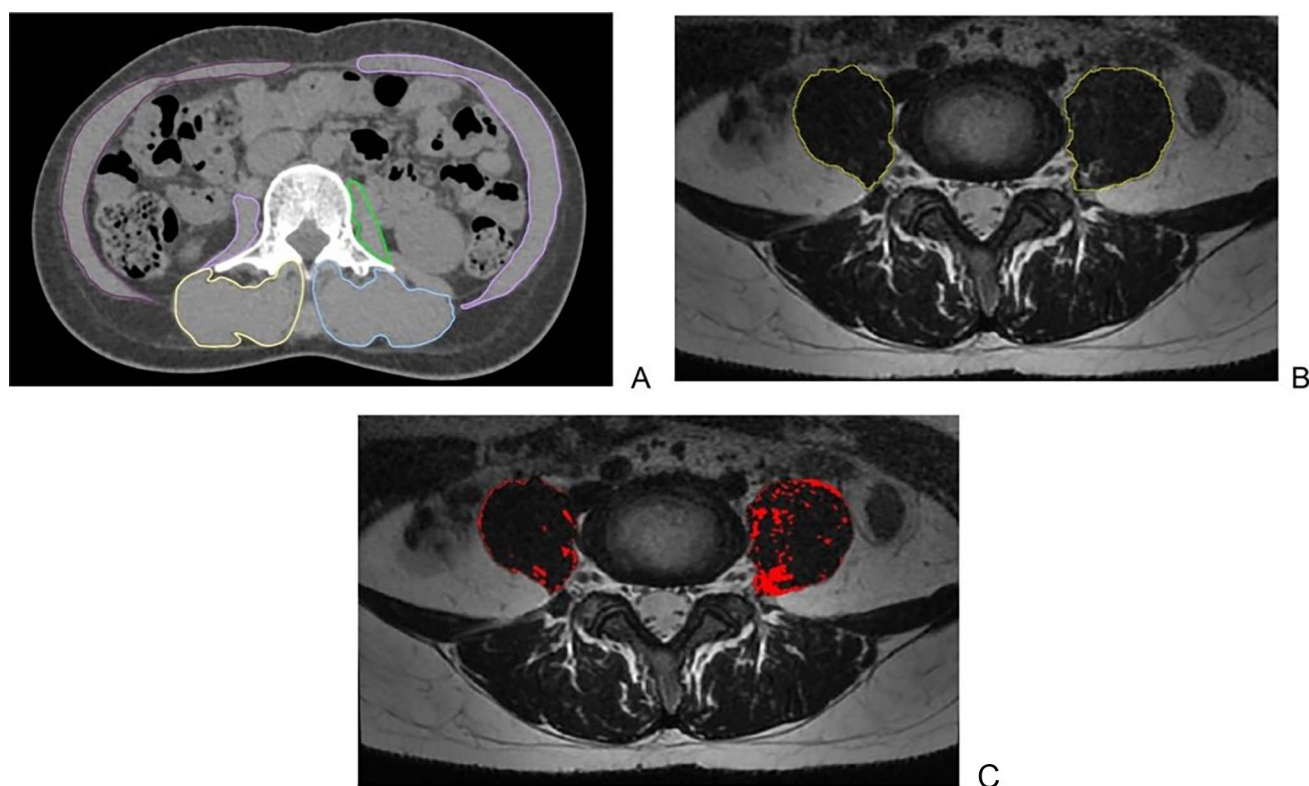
Axial CT and MRI images assessing muscle mass and quality in sarcopenic patient. A 31-year-old woman. Axial CT image of the abdomen at the L3 level shows region of interest (ROI) delineation of all truncal muscles along muscle boundary to CSA evaluation. B A 67-year-old man. An axial MRI image of the abdomen at the L3 level
